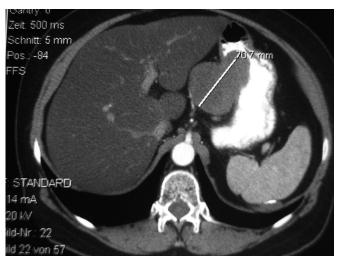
Preoperative CT-scan detecting a large gatstric submucosal gastrointestinal stromal tumors on a small curvature side.
